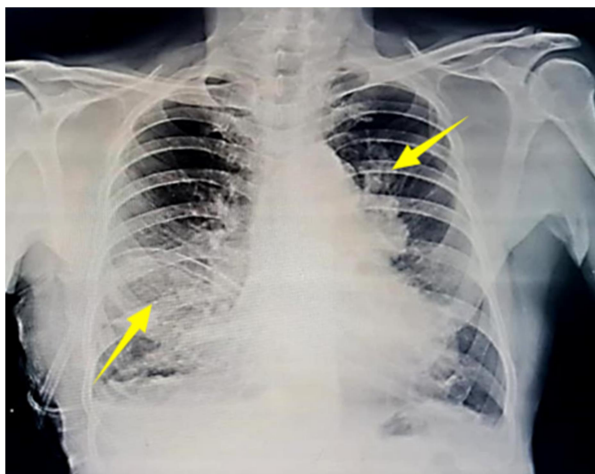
Chest X-ray showing lobulated mediastinal mass in the left upper lobe with ICD in situ and right sided haemothorax
